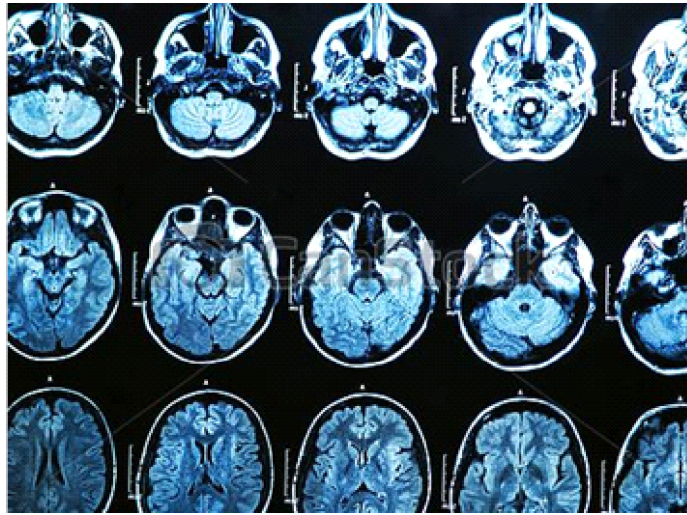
An MRI scan of the human brain provides different views
